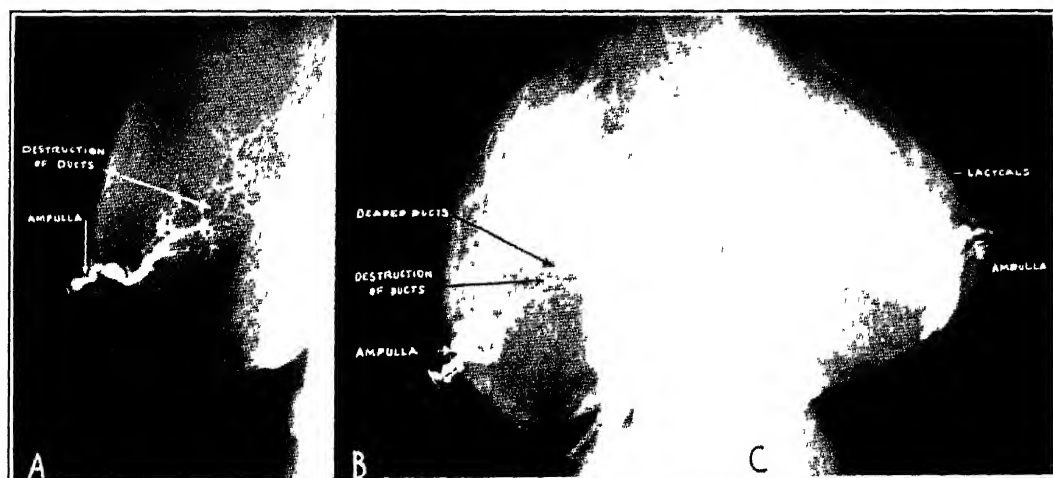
A*, One duct injected with thorotrast Its outer segment is normal but the ramifying lacteals are displaced, invaded and destroyed Note the "beading effect" due to invasion *B*, Two ducts were injected with thorotrast and the same destructive invasive process is seen The ducts appear like a filamentous spiderweb *C*, Note the dense network of dilated, convoluted, branching ducts which the asymptomatic right breast has as compared with its malignant mate (Am J Roentgenol, March, 1938)
